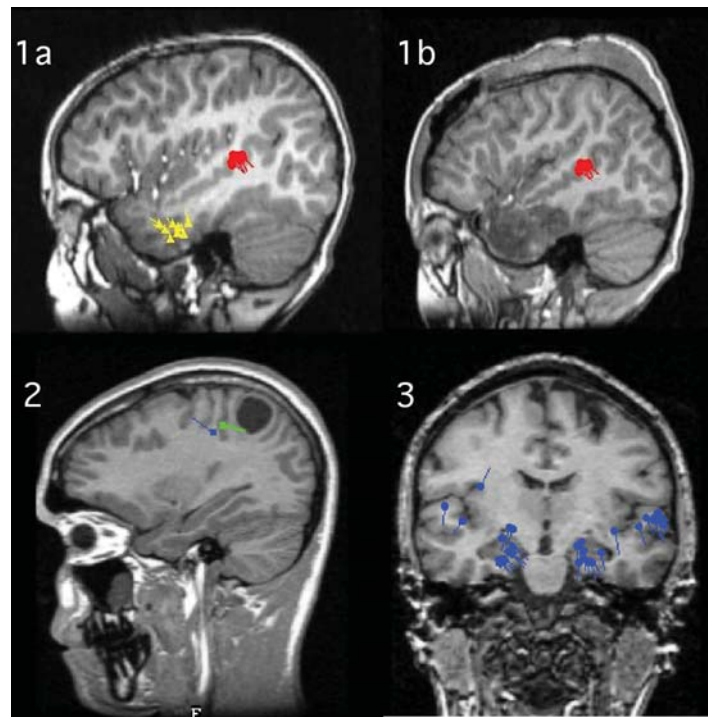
MEG evoked responses. 1a: pre-operative MRI with superimposed MEG derived localisation of interictal epileptiform activity (yellow triangles) and receptive language areas (red circles) in a patient with focal epilepsy undergoing pre-surgical evaluation. 1b: post-operative MRI from the same patient showing the margins of anterior temporal lobe resection and intact receptive language regions. 2: source localisation of somatosensory (green) and motor (blue) activation in a patient with a cystic parietal lobe lesion. 4: MEG-derived profiles of activation during a simultaneous auditory and visual memory task in a healthy control subject. (Images courtesy of Dr E Castillo, Division of Clinical Neurosciences, Houston).
